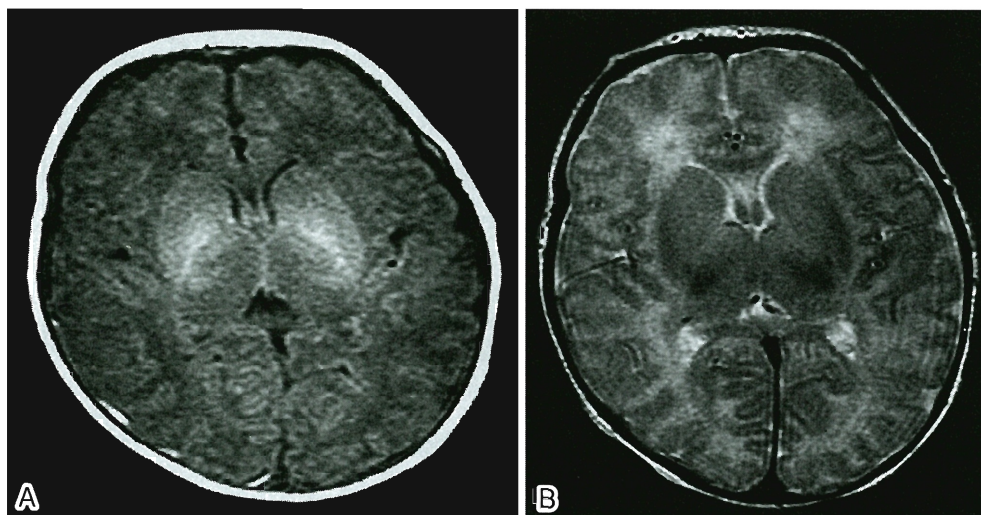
MR images of Patient 8
